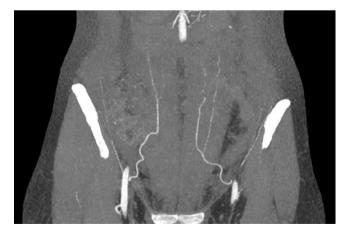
Computed tomographic angiogram (CTA) of the abdominal wall vasculature, demonstrating the deep inferior epigastric artery (DIEA) pedicle
